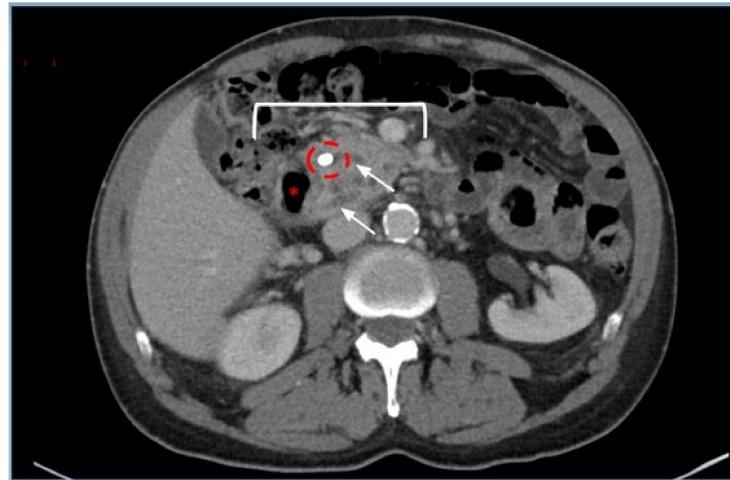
CT of the abdomen at the level of the pancreatic head. The pancreas (white bracket) is seen surrounding the second part of the duodenum (asterisk) compatible with annular pancreas. A 6mm calcification (circled) is present in the region of the minor papilla (arrows indicate pancreatic ducts)
